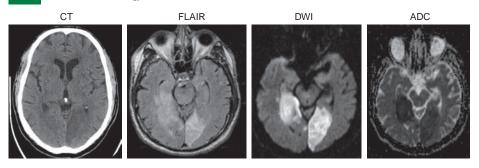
A 69-year-old man had new onset of right-sided visual blurring and right-sided numbness. Neuroimaging studies demonstrate left occipital and right medial temporal infarcts; the right side temporal infarct was harder to be visualized on CT. (Courtesy of Dr. Lotfi Hacein-Bey.)
